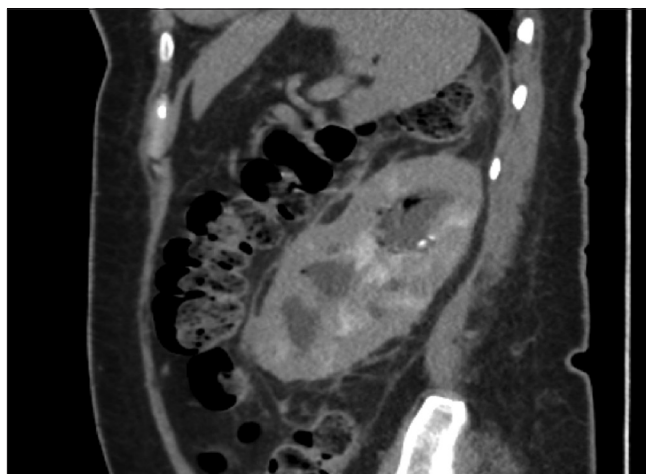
Abdominal computed tomography, findings are consistent with complicated left pyelonephritis and emphysematous pyelonephritis
